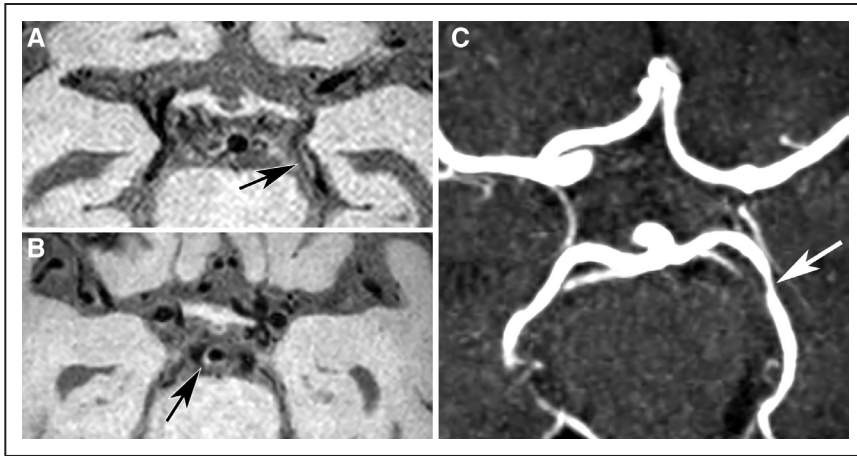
A 72-year-old female patient with a left partial anterior circulation infarct. A, On transverse T1-weighted volumetric isotropically reconstructed turbo spin echo acquisition images, an eccentric, focal lesion was found in the P2 segment of the left posterior cerebral artery (arrow). Also, an eccentric, focal lesion (arrow in B) was observed in the basilar artery without causing luminal stenosis (arrow in C). C, Transverse time-of-flight magnetic resonance angiography shows an asymptomatic stenosis of the P2 segment at the same location as the vessel wall lesion (arrow).
